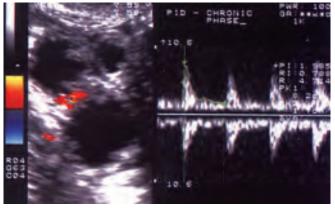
"Cogwheel" sign produced by hyperechogenic knots and pseudopapillomatous structures is typical of chronic phase of PID. Color Doppler helps to differentiate suspicious morphology
